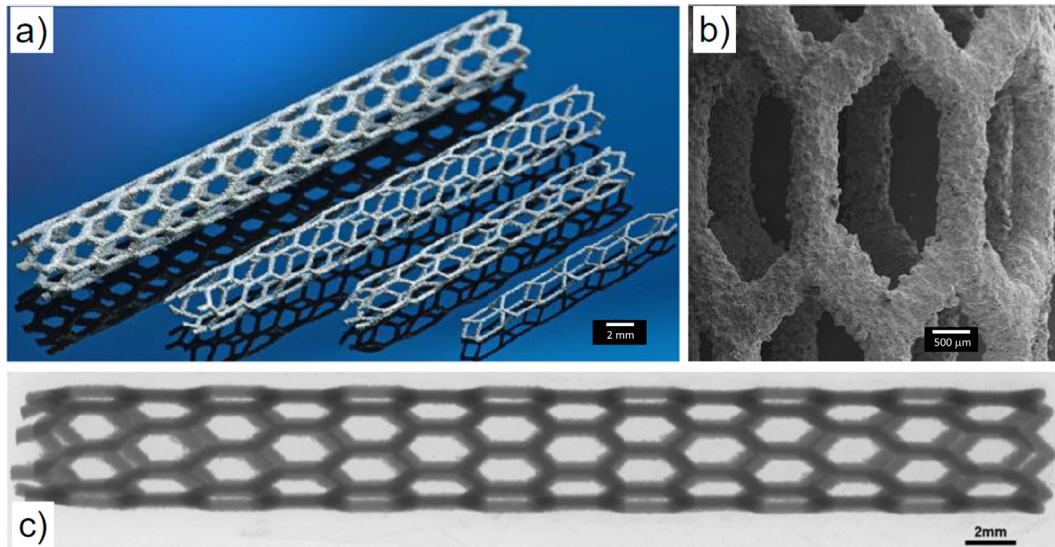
The 3D-printed cardiovascular stent produced by Wen et al.: a) sample photo, b) SEM. image, and c) radiographic image. Scale bars for (a) and (b) were improved for better visibility. Reprinted from [80], with permission from Elsevier.
